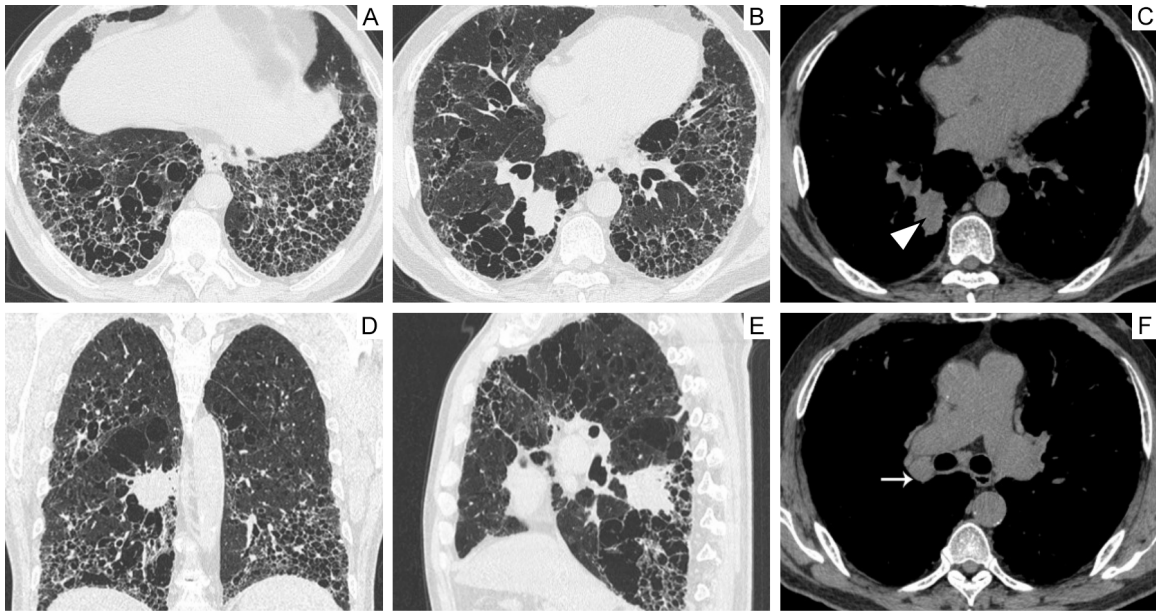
A 59-year male patient with LAC in the test set, showing T-UIP pattern of IPF. (A-C) Axial chest CT showed a solitary solid nodule (white arrow head) located in the lower lobe of the right lung. Coronal (D) and sagittal (E) HRCT show lobulation, spiculation and vessel convergence. Lymph node enlargements are shown in the right hilus of lung with white arrow (F). Notes: LAC, high-grade lung adenocarcinoma; T-UIP, typical usual interstitial pneumonia; IPF, idiopathic pulmonary fibrosis; HRCT, high-resolution computed tomography.
